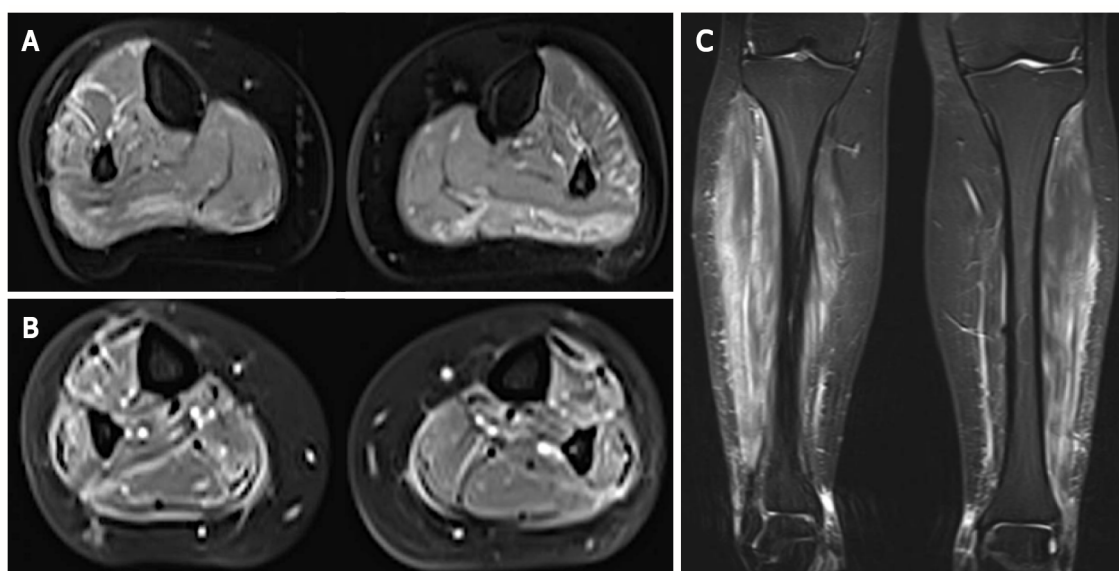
Magnetic resonance imaging of the calves in axial and frontal views. A and C: Demonstration of high signal on T2-weighted images in muscles from posterior and lateral compartments of the legs as well as in their surrounding fascia; B: This finding was accentuated on gadolinium-enhanced fat-suppressed T1-weighted images, suggestive of myositis and fasciitis.
